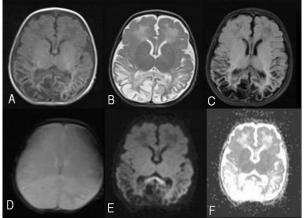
T1WI (A), T2WI (B), FLAIR(C), GRE (D), DWI (E), ADC (F) showing cystic encephalomalacia with restricted diffusion in splenium. Cystic encephalomalacia appears hypointense on T1WI and FLAIR and hyperintense on T2WI. Restricted diffusion in splenium appears bright on DWI with low ADC values
